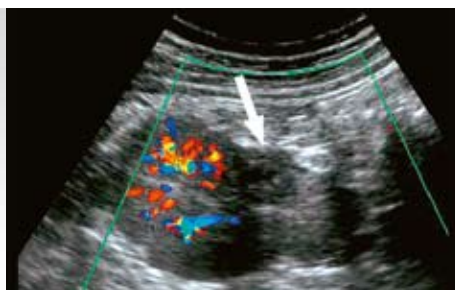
Color Doppler US did not reveal any residual vascularity or vascular complication such as renal arterio-venous fistula and false aneurysm.
